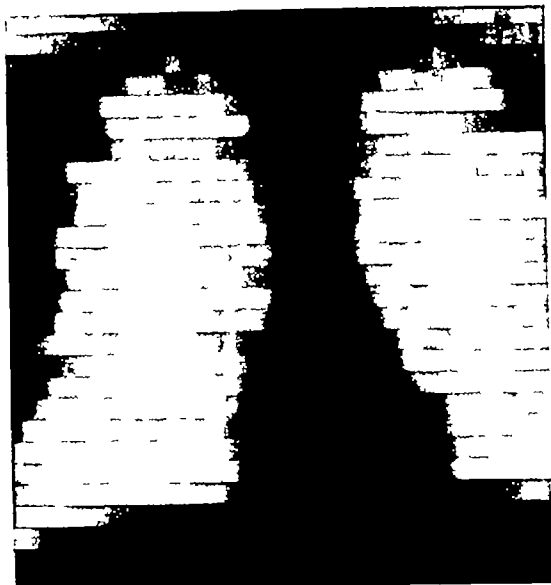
Roentgen kymogram of Case 1, before operation. Note that pulsation is diminished on both borders of the cardiac shadow.
